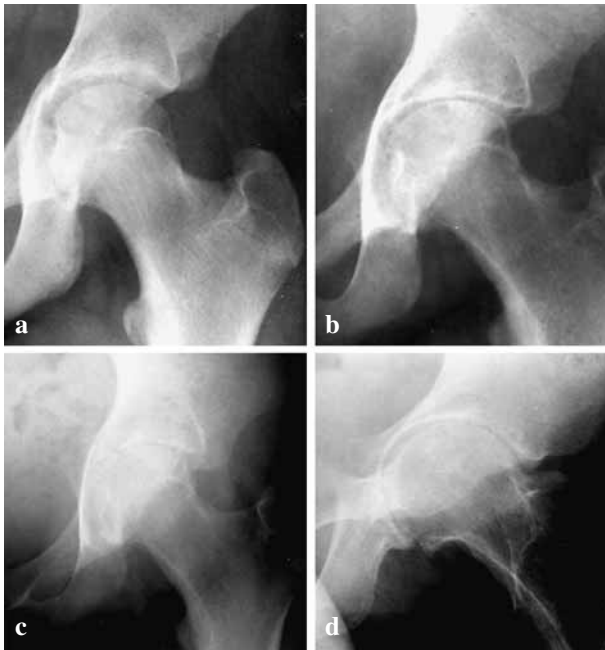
Progressive deterioration of the joint space of the left hip as shown by comparison of radiographs taken in April 1997 (a), August 1997 (b), October 1997 (c) and 1998 (d).
